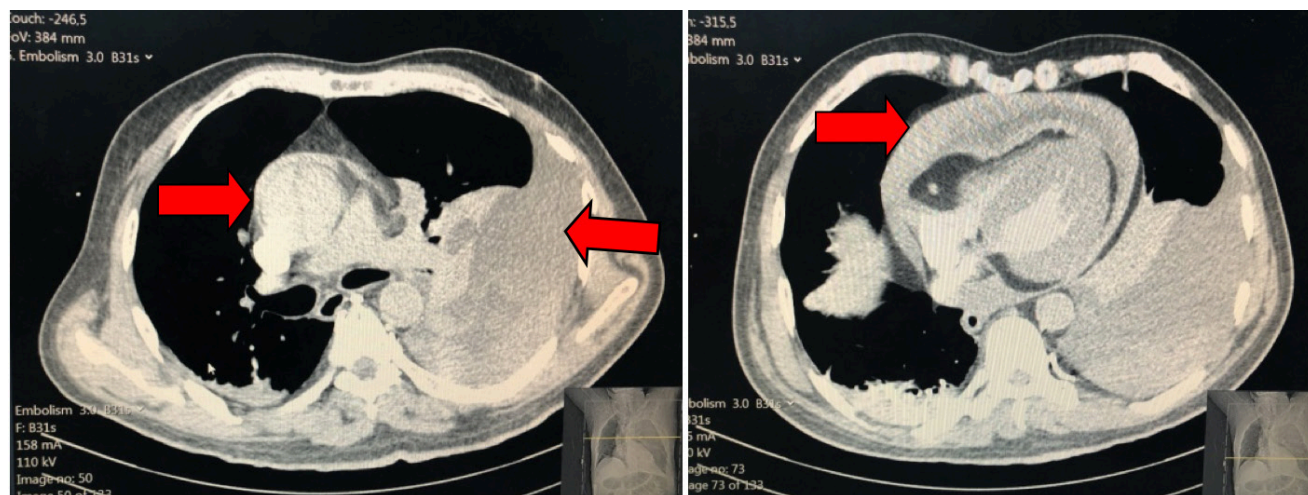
Aneurism in the ascending aorta, dissection, fluid around the pericardium and the left lung (hemorrhage?) in dynamic thorax CT angiography
